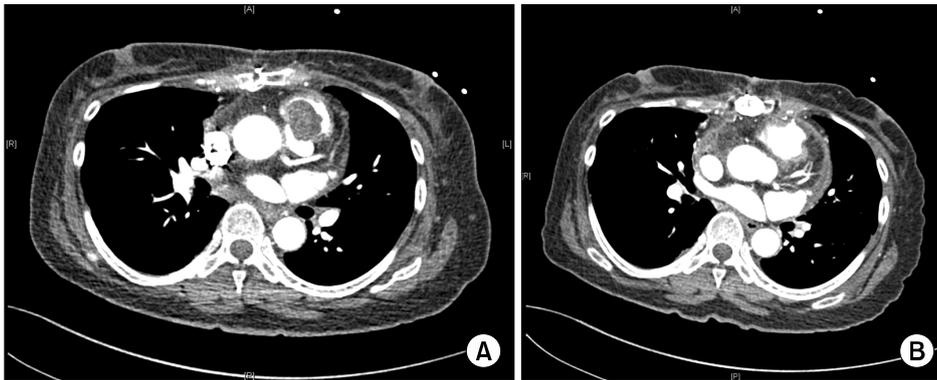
(A) Preoperative computed tomography: 2.5×2.5 cm mass at the interventricular septal base of the right ventricular outflow track. (B) Postoperative computed tomography: complete mass resection of the pulmonary trunk and right ventricular outflow track.
